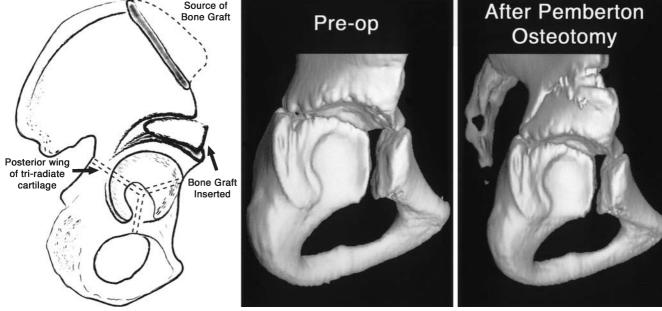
Pemberton acetabuloplasty. a Nature of the Pemberton acetabuloplasty. b Preoperative and postoperative three-dimensional computed tomography (3D CT) scan of a
